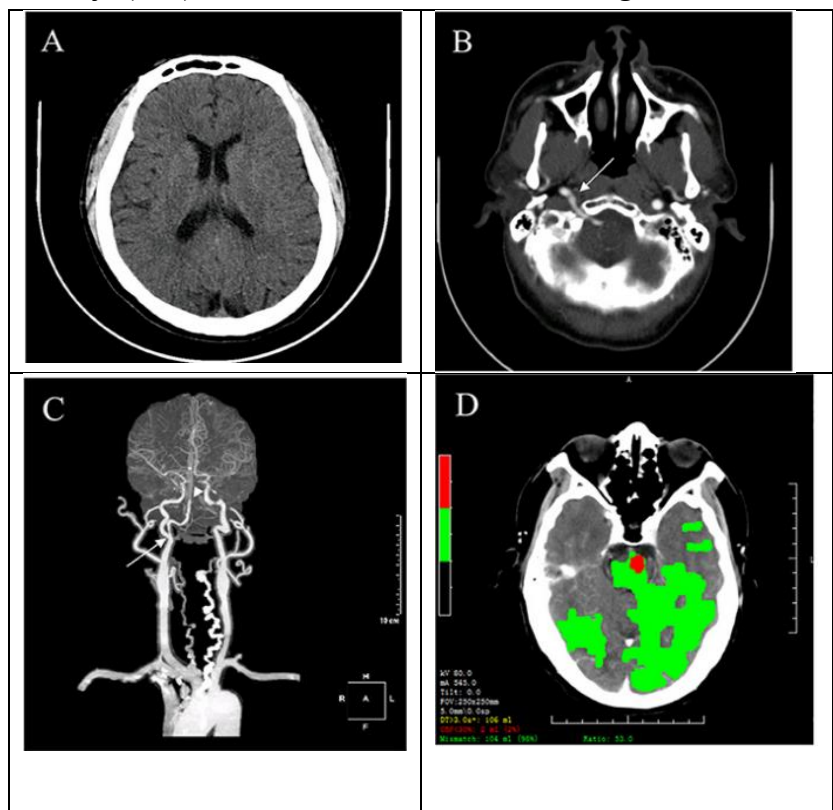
shows a multimodal neuroimaging examination performed prior to surgery. (A) Computed tomography (CT) was used to rule out intracranial haemorrhage. (B) A cross-sectional contrast CT examination indicated an improper anastomosis. (C) Anterior-posterior CT angiography revealed basilar artery blockage. (D) The mismatch volume was calculated by automatically evaluating the volumes of the infarct core and penumbra from CT perfusion.
